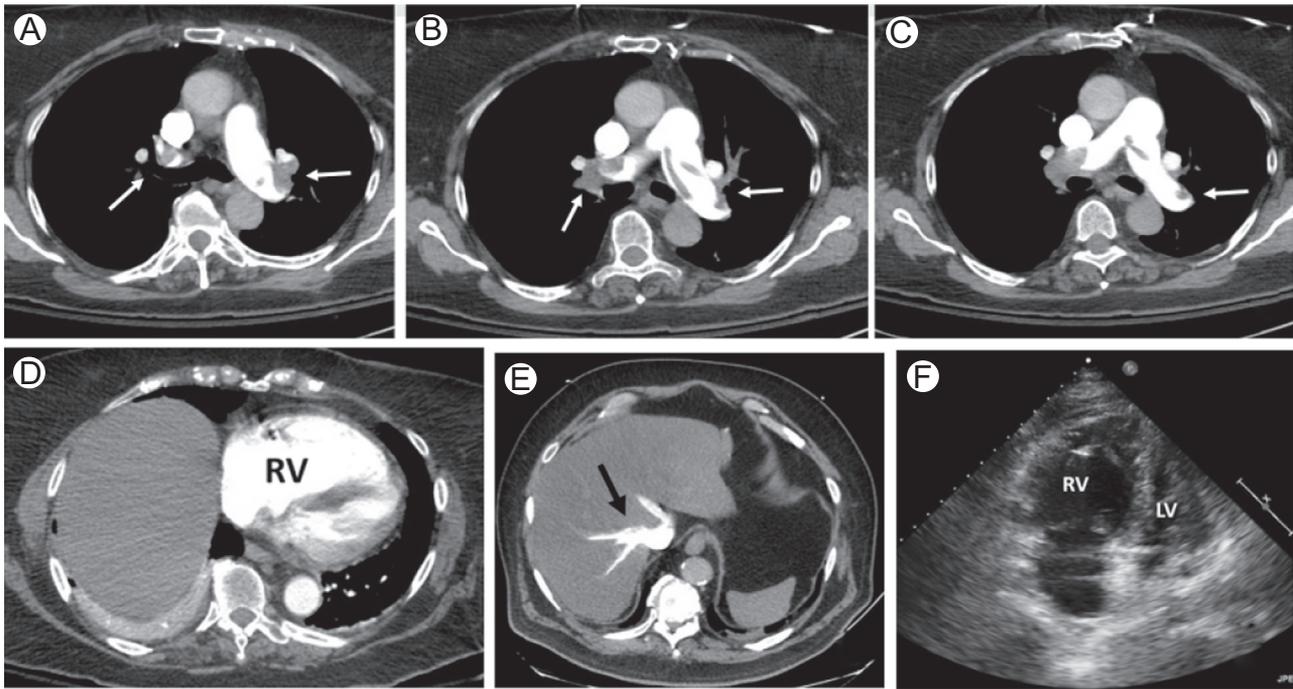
Figure A 46 year-old man presented with acute dyspnea and extensive acute pulmonary embolism (PE) (A-C). Heart rate was 120/minute, blood pressure 136/72 mm Hg, and oxygen saturation 94% on 4 L by nasal cannula. The right ventricle was dilated on chest computed tomographic angiography (D) and there was reflux of contrast into the inferior vena cava and hepatic veins (E). The right ventricle was severely dilated (and hypokinetic) by echocardiography (F). The patient was thus, intermediate-risk PE. There was extensive residual right leg deep venous thrombosis. He was anticoagulated and considered for catheter-based therapy. However, in the emergency department, he developed near syncope, with blood pressure dropping to 92/48, and tachypnea at 30 breaths/minute. The heart rate increased to 140/minute and oxygen requirement increased to 4 L and then to 60% by facemask. He received 1 L of intravenous fluid with no blood pressure improvement. The rate of progressive deterioration was believed too rapid for the standard 2-hour regimen. Based this (*although still intermediate-risk based on his blood pressure*), his young age, and perceived low risk for bleeding, he was given intravenous tissue-type plasminogen activator (30 mg over 10 minutes and remaining 70 mg over the subsequent 20 minutes). Over the next 4 hours, the heart rate slowed to 92/minute, blood pressure increased, and O₂ requirement decreased to 2 L/min. No major bleeding occurred. If there had been rapid access to catheter-based therapy, it is feasible that approach would have also been successful also.
